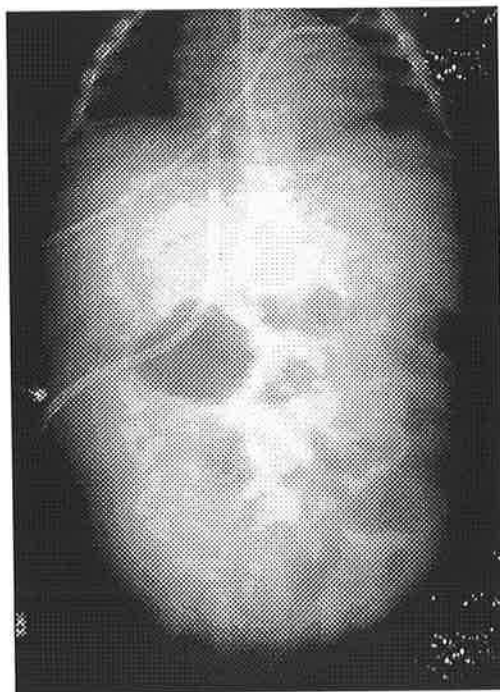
+ 69: Radiograph of the catheter in situ in the right and left renal vein.
